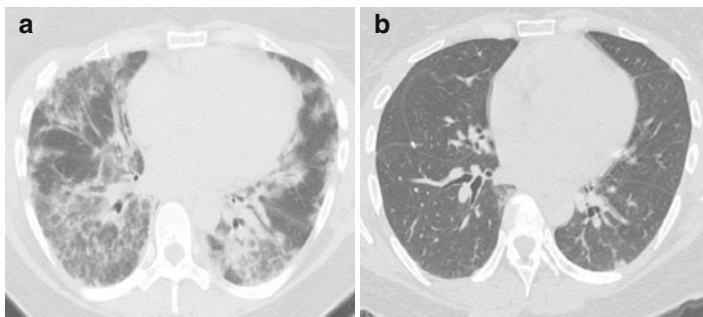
High resolution computed tomographic images showing the cellular variant of non-specific interstitial pneumonia. (a) Before treatment, and (b) improvement in infiltrates after treatment with corticosteroids
